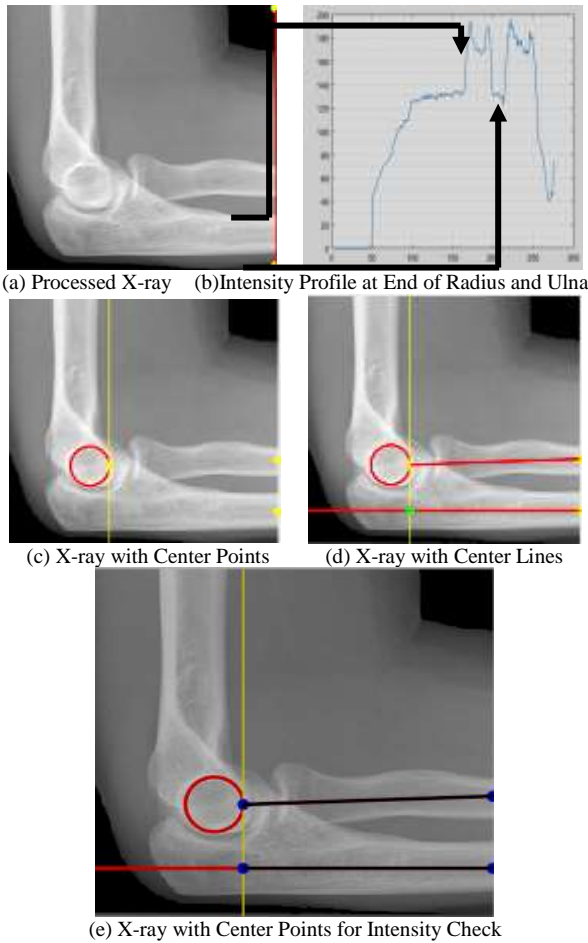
Processed X-ray for Radial or Ulnar Distortion Detection. (a) Shows the X-ray Image Processed Till the end of Radius and Ulna Bones to Check Intensity. (b) Shows the Intensity Profile at the End of Both of the Bones. (c) Shows the X-ray with Center Points Detection at the End of Ulna and Radius. (d) Shows the Processed X-ray with Center Lines in Middle of Forearm Bones. (e) Shows X-ray with Multiple Points at the Center Lines to Check any Fracture.
